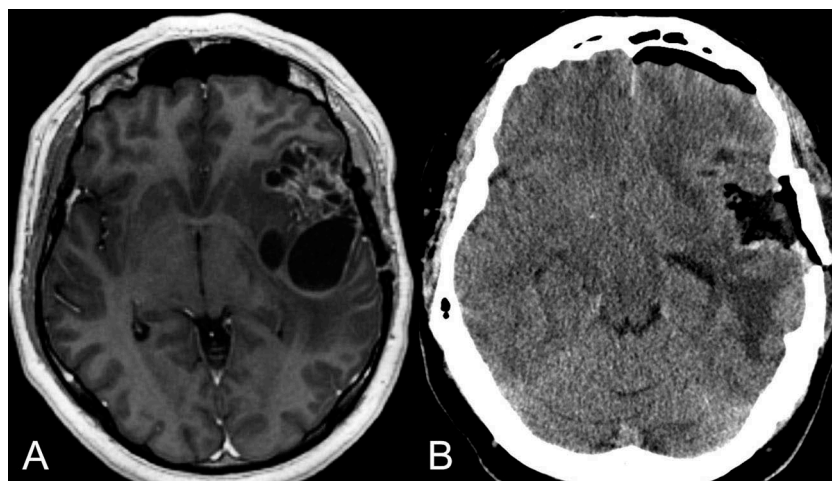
A) Pre-operative MRI of 31 year-old man who one year previously underwent outpatient awake craniotomy for an anaplastic astrocytoma followed by radiation and chemotherapy. He now presents with recurrence and undergoes surgery under general anesthesia. Note the edema and mass effect. B) CT 4 hours post-operatively and 2 hours prior to discharge from DSU.
